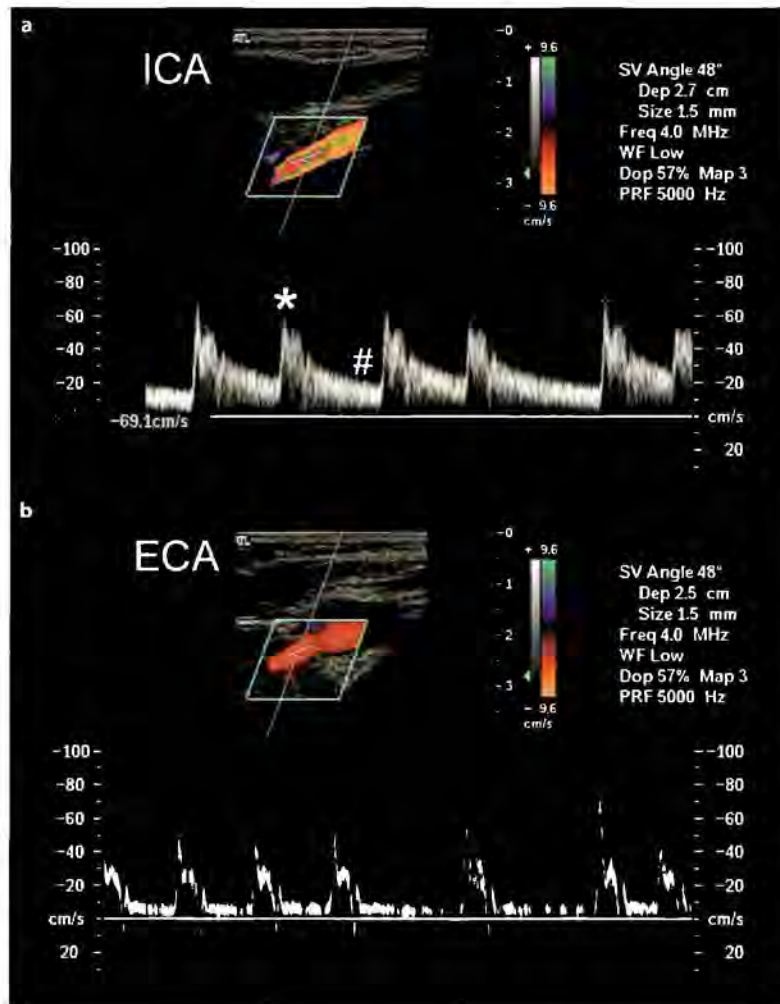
Color and pulsed Doppler images, used to analyze the internal (a) and external (b) carotid arteries (ICA, ECA). The color Doppler mode allows identification of the vessel flow, while pulsed Doppler allows waveform analysis. One parameter, the resistive index, can be calculated by comparing the systolic peak flow (*) with the end-diastolic flow (#). The end-diastolic flow in the ICA is higher than in the ECA due to lower vascular resistance. Changes in vascular resistance may be of use in monitoring treatment
